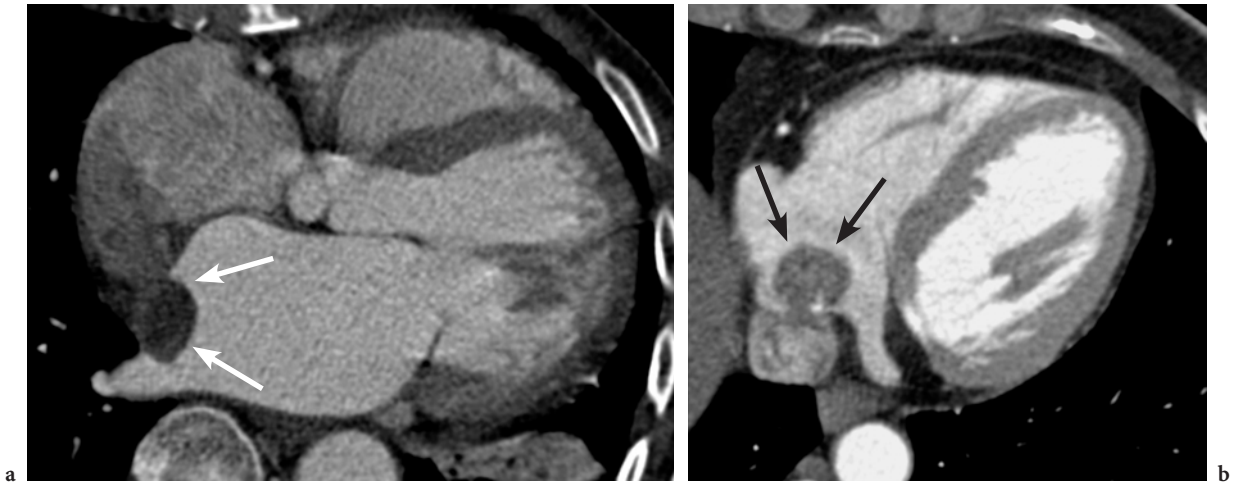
Retrospectively cardiac gated 16-slice CT of cardiac myxomas within the left atrium (a) and right atrium (b). Both myxomas (arrows) show a typical, rather low attenuation; note the small calcifications (b)
